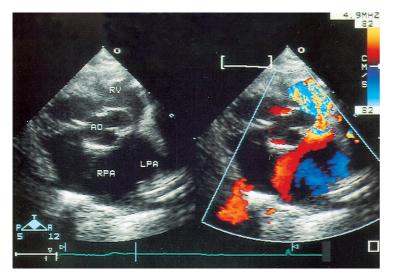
Preoperative echocardiography (parasternal short axial view) shows a large ventricular septal defect, a hypoplastic pulmonary annulus with a rudimentary pulmonary valve, and markedly dilated main pulmonary trunk and its branches. The severe pulmonary regurgitant flow at the right ventricular outflow tract could be identified from the color Doppler images. RV = right ventricle; AO = aorta; RPA = right pulmonary artery; LPA = left pulmonary artery.
